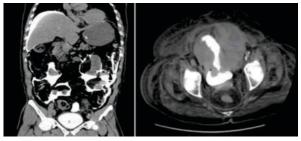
CT Cystogram image showing intraperitoneal bladder rupture
